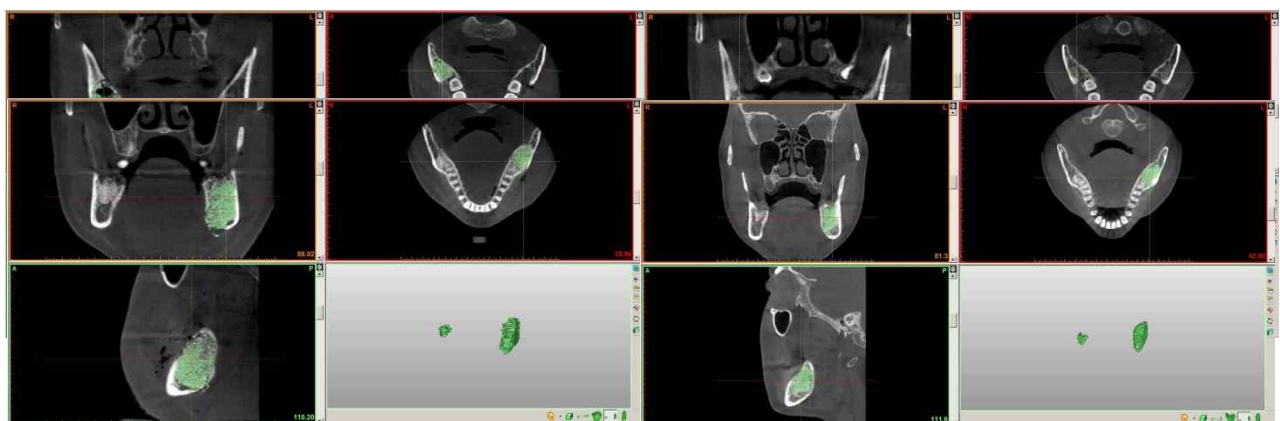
Case 15 (Mn. Post. Bilateral) Immediate Post-op & POD12M CBCT
